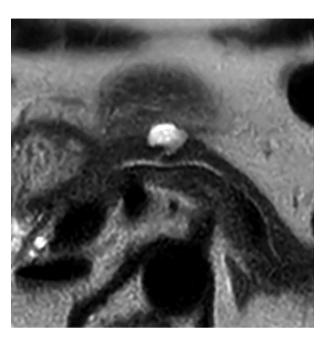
Branch-duct IPMN. Axial T2-weighted image in a 77 years old male shows a pancreatic cyst in communication with MPD
